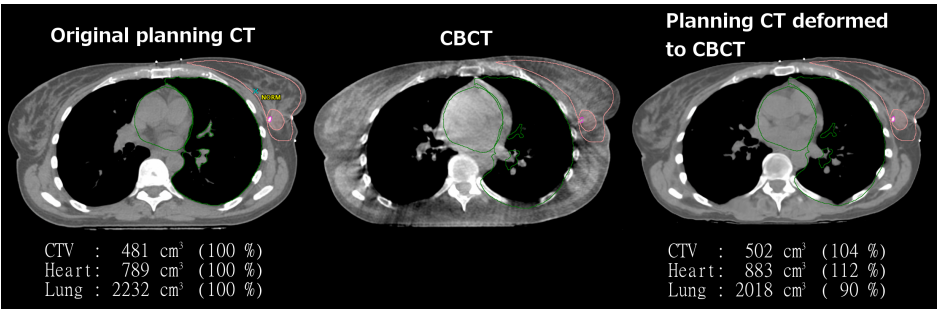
Overview of the change in CTV, heart and lung volume from CT room to treatment. The original planning CT, a CBCT acquired at fraction 2, and the planning CT deformed to the CBCT. All depicted structures are the non-deformed structures (CTV, CTV cavity, clips, heart and ipsilateral lung) from the planning CT. The volumes of the CTV, heart and ipsilateral lung are shown together with the percentage difference relative to the volume at planning CT (in parenthesis). The ipsilateral lung is reduced to 90 % of the original volume indicating that the patient might have arched her back to reach the gating window in the treatment room. Shown for patient 29.
